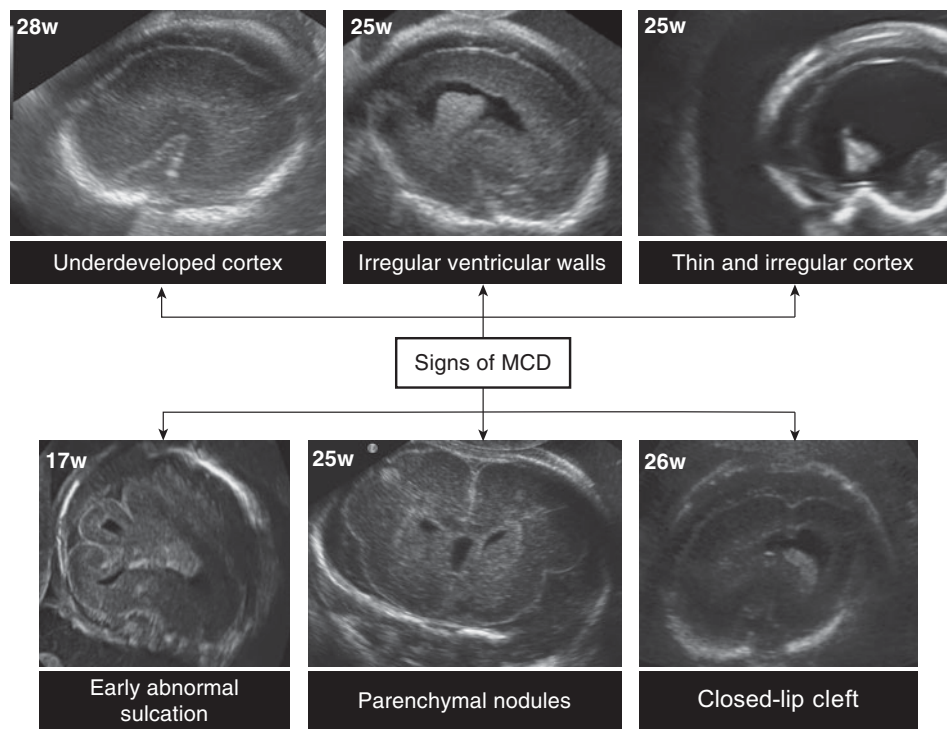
Ultrasound signs of malformations of cortical development.
